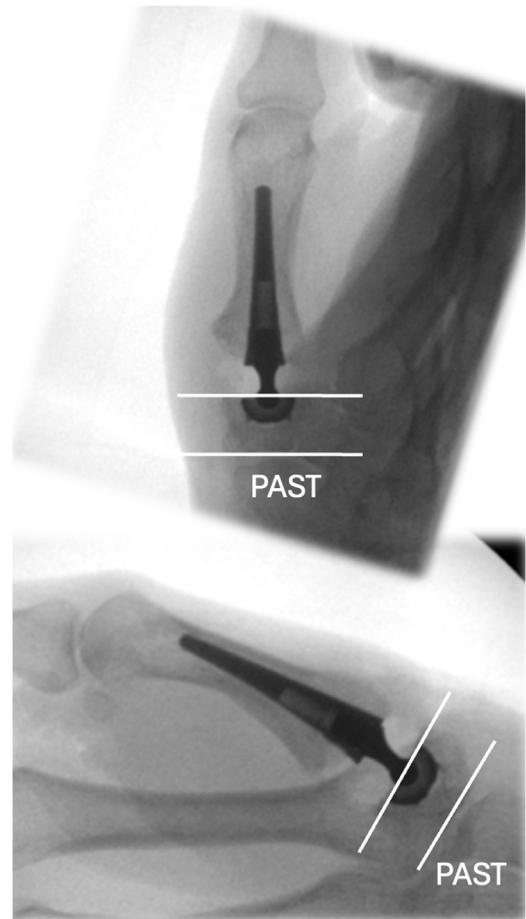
Radiograph demonstrating cup alignment parallel with the proximal articular surface of the trapezium (PAST) on posteroanterior and lateral view.
